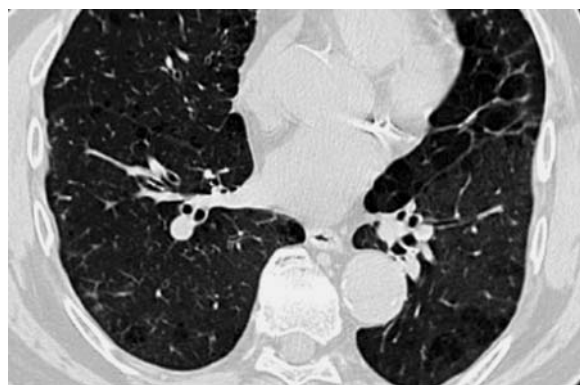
Expiratory bronchial collapse in a COPD patient. Transverse thin slices at a full inspiration and b expiration after MDCT, and c CT bronchograms obtained from the same data (*left*: inspiration; *right*: expiration). Expiratory bronchial collapse is seen in the segmental and subsegmental bronchi within the lower lobes (b, c)
